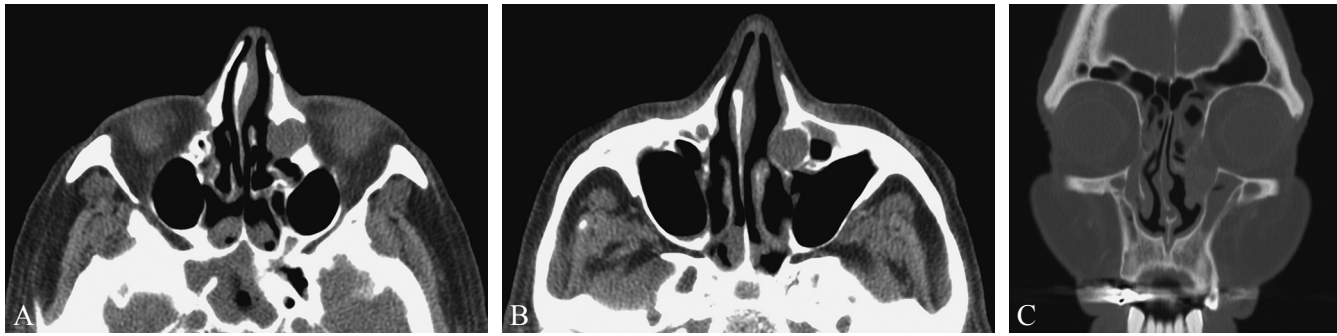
Axial (A, B) and coronal (C) CT images showing the a mass in correspondence of the left lacrimal sac with erosion of the nearby bone.
